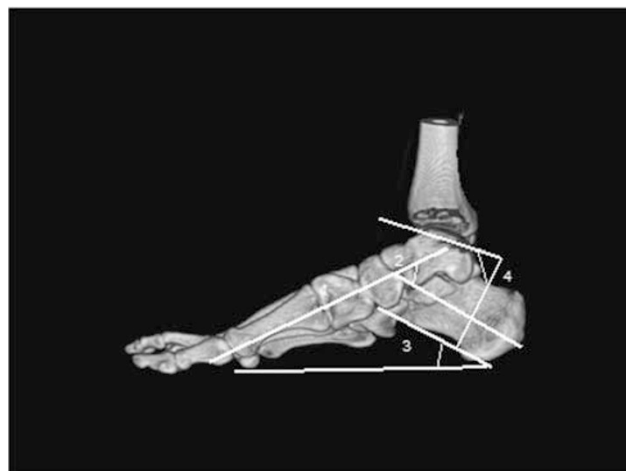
Lateral radiography: (1) talar–first metatarsal angle, (2) talocalcaneal angle, (3) calcaneal–ground angle; 4–tibio-calcaneal angle. Talar–first metatarsal angle formed by the intersection of the long axis of the talus and the long axis of the first metatarsal. Normal is $<4^\circ$. Talocalcaneal angle lateral: formed by the intersection of the long axis of the calcaneus and the long axis of the talus. Normal is $<30^\circ$. Calcaneal–ground angle: formed by the intersection of the long axis of the calcaneus and the axis of the ground. Normal is $<30^\circ$. Tibio-calcaneal angle: formed by the intersection of the perpendicular to long axis of the calcaneus and the long axis of the surface articular of the tibia. Normal is 90° .
